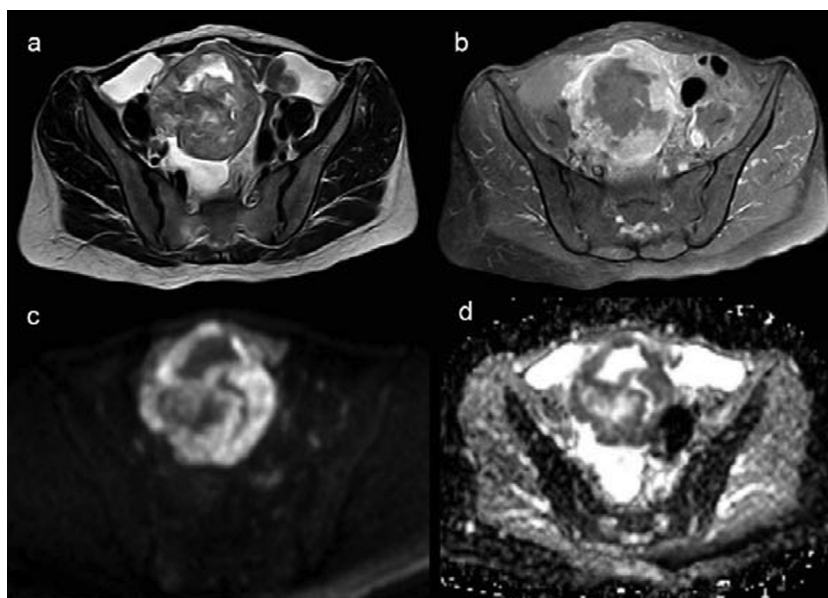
Axial images of the pelvis, (a) T2, (b) Post contrast T1 fat suppressed image, (c) DWI (b -value 1000 s/mm^2) and (d) ADC map. A right ovarian solid lesion with central breaking down is noted. The solid component displays intermediate signal in T2, avid enhancement in post contrast sequence, bright signal in DWI and low signal in ADC map denoting diffusion restriction. The calculated ADC value of the solid component was $0.8 \times 10^{-3} \text{ mm}^2/\text{s}$ and diagnosis of mucinous cystadenocarcinoma was made on pathology.
